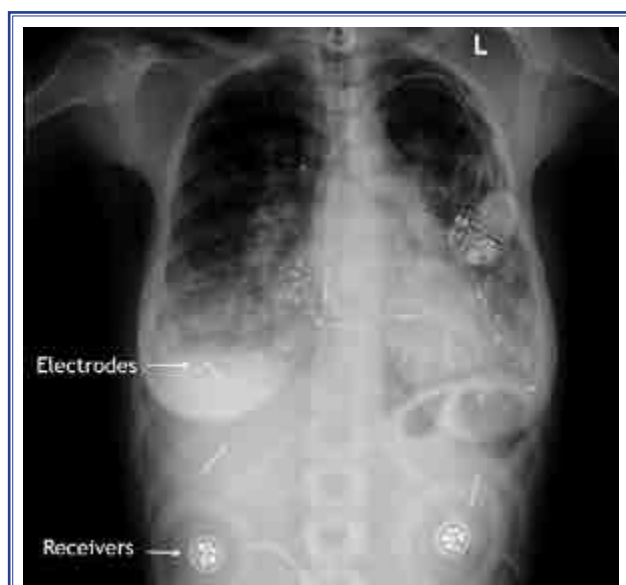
Chest X-ray of the patient revealing components of the diaphragmatic pacing system.
